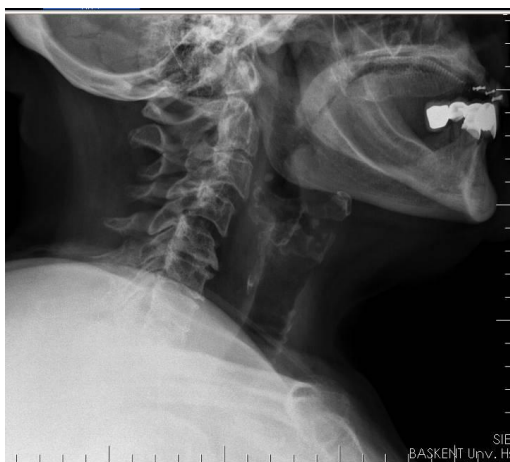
Preoperative lateral cervical X-ray shows that there wasn't a compression fracture in any level or lytic lesion, but does show spondylopathic features.
